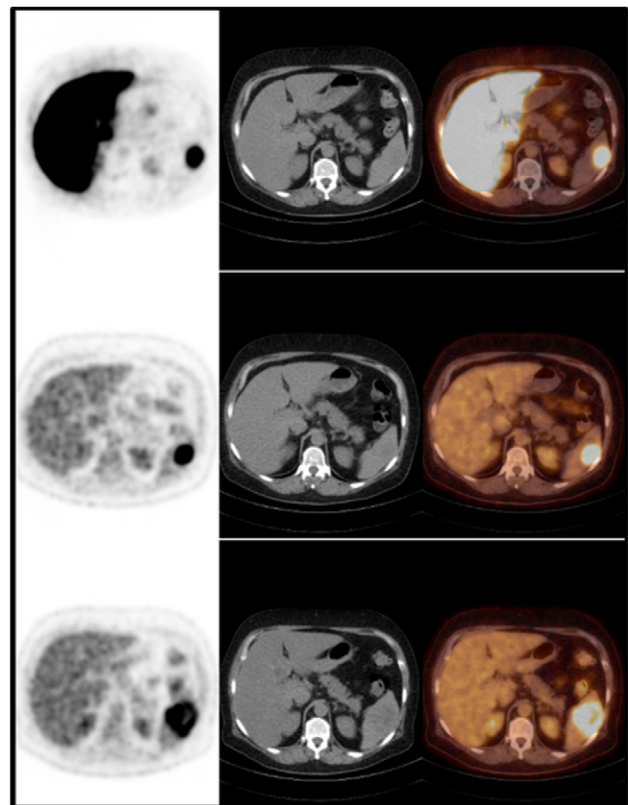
PET/CT axial views of the spleen metastasis from left to right and top to bottom: PET, CT and PET/CT fused images with [^{18}F]-FES PET on 14 February then [^{18}F]-FDG PET on 6 February 2014, and [^{18}F]-FDG PET on 25 April 2016
